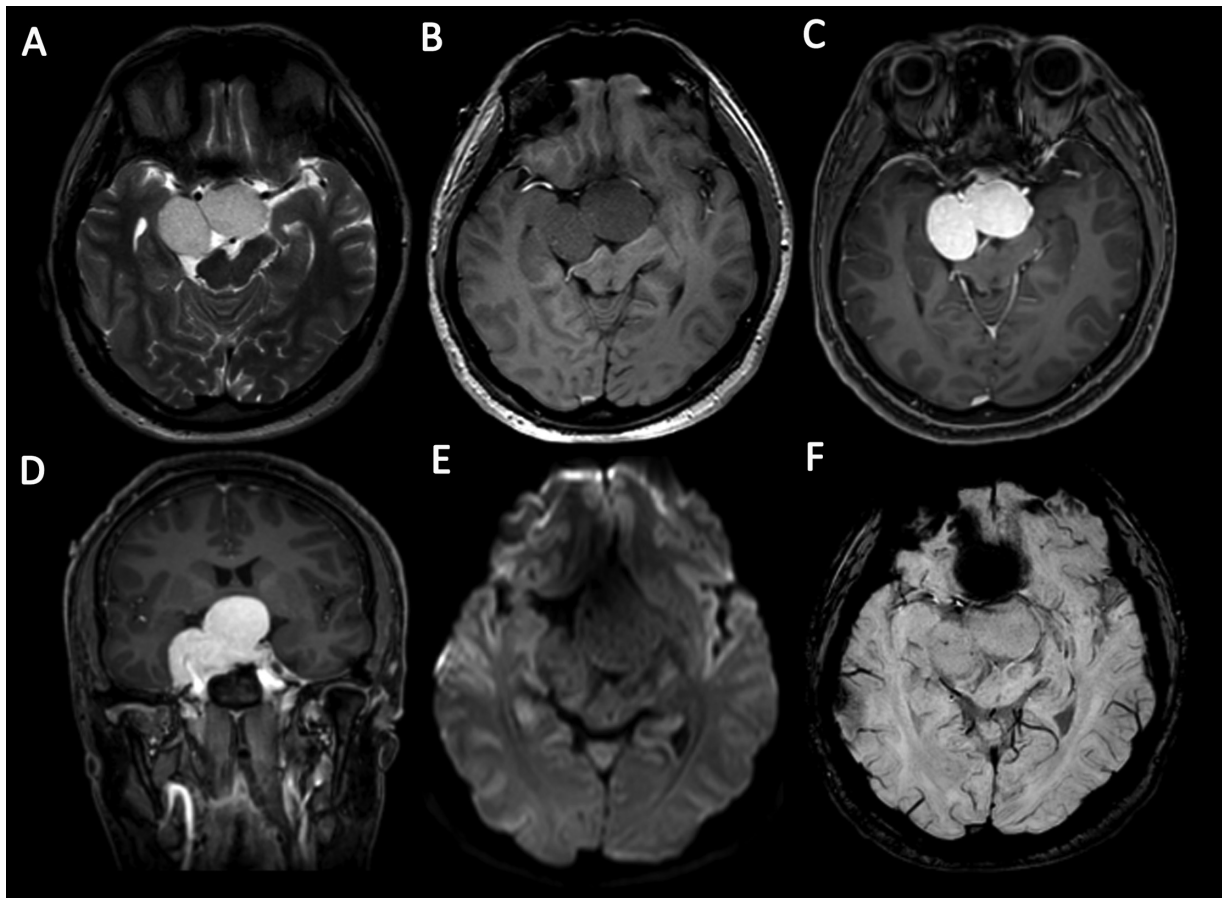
A right cavernous sinus cavernous hemangioma extending to the intrasellar and suprasellar areas in a 37-year-old male patient with a history of progressive headache and blurring of vision. (A) Axial T2-weighted image (T2WI) demonstrates a large lobulated shape mass with a homogeneous hyperintense signal compressing the optic chiasm. The mass (B) is hypointense on axial T1-weighted image (T1WI) and (C) shows homogeneous intense enhancement on contrast-enhanced axial T1WI and (D) contrast-enhanced coronal T1WI. (E) No diffusion abnormality is detected on diffusion-weighted imaging (DWI). (F) There is no “blooming artifact” on susceptibility-weighted imaging (SWI).
